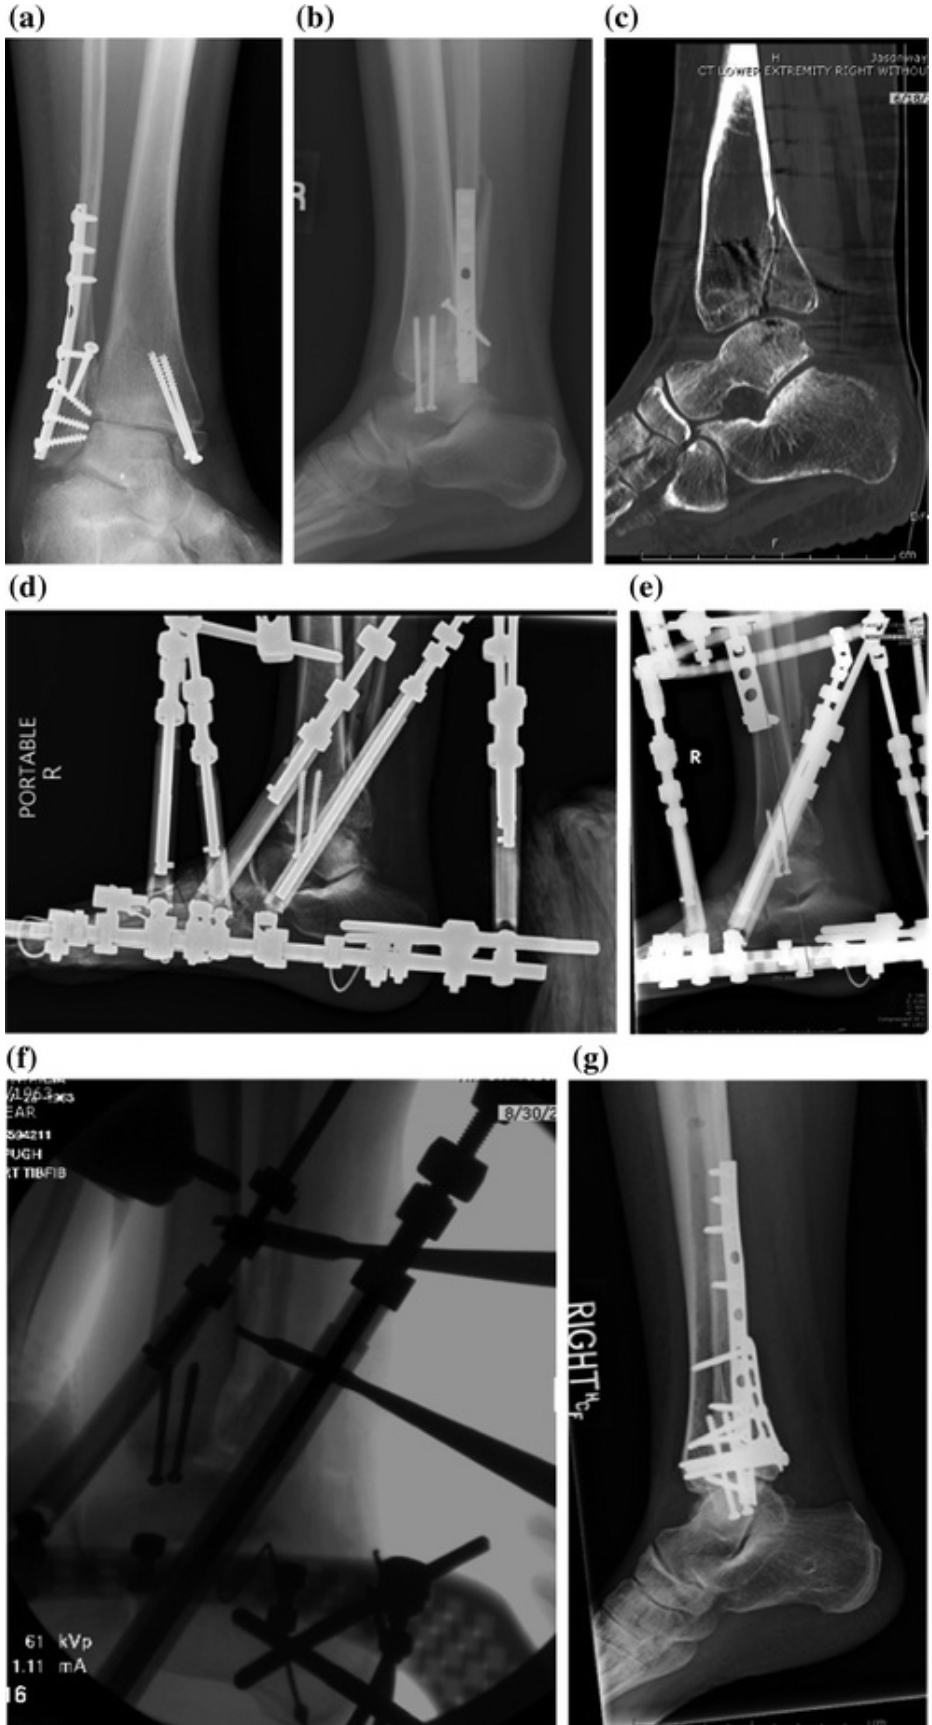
40-year-old patient eight weeks after treatment for a trimalleolar ankle fracture a mortise, b lateral and c computed tomography of malunited medial malleolus, non-united lateral and posterior malleolus with posterior ankle subluxation d application of multiplanar external fixator for joint distraction and reduction e after correction of joint subluxation f intraoperative view of repair of posterior malleolus g twenty-four month follow up with joint reduction and fracture union
